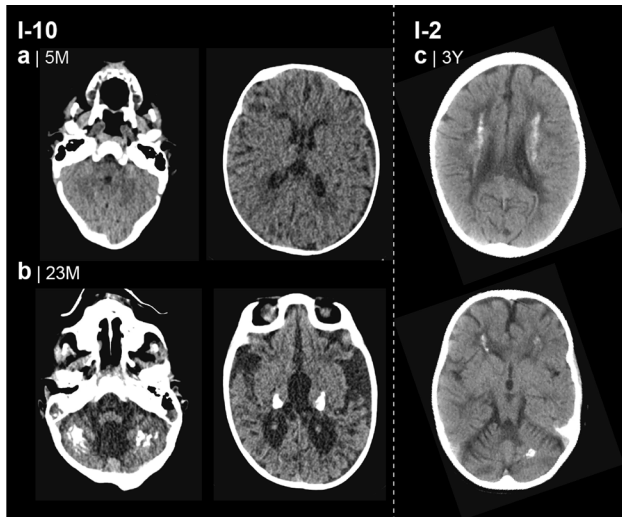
Calcium deposits in *AARS1*-related disorder. (a) Computed tomography (CT) imaging of I-9 was performed at 5 months and 23 months of age. On early imaging studies calcifications were not evident, but (b) follow-up imaging at 23 months demonstrated calcifications in the cerebellum and thalami bilaterally. (c) CT in I-2 at 3 years of age reveals the presence of calcifications in the cerebral and cerebellar white matter.
